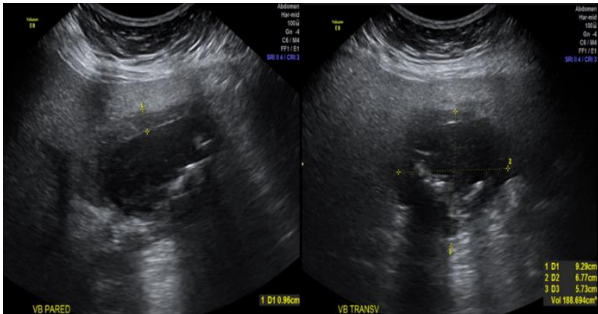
Sonography of the liver gallbladder and bile ducts was performed with evidence of exacerbated chronic lithiasic cholecystitis with a wall >0.94 cm, and a size of the gallbladder of 9.3 x 5.7 x 5.7 cm.
